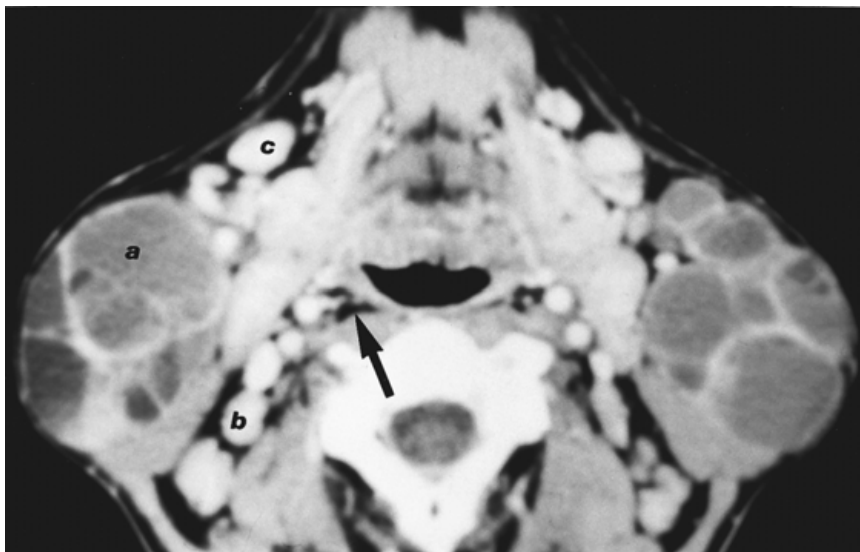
Human immunodeficiency virus–related parotid disease. Axial computed tomographic scan of the neck shows (a) multiple cystic lymphoepithelial lesions within the parotid space. There are also (b) multiple enlarged spinal accessory chain lymph nodes in the posterior cervical space and (c) multiple enlarged internal jugular chain lymph nodes within the submandibular space. The straight arrow points to fat within the retropharyngeal space.
